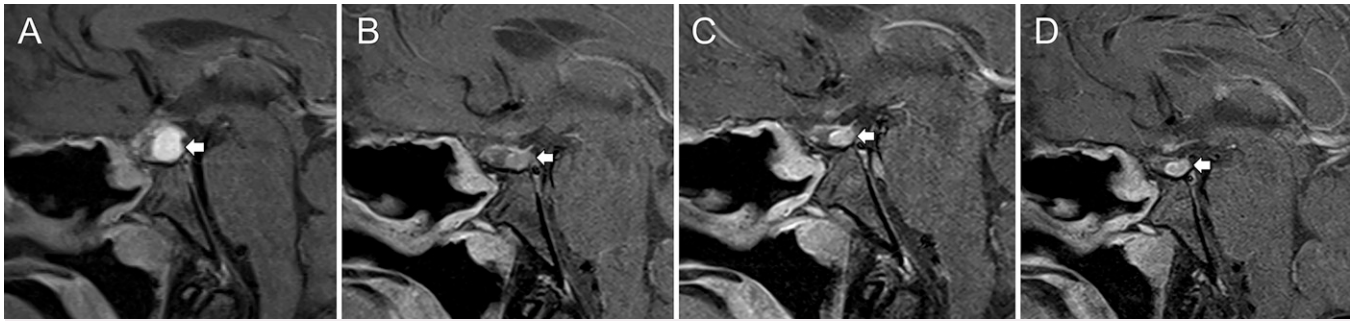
MRI at the second recurrence through treatment. A: Sagittal postcontrast T1-weighted MRI at the second recurrence showed a recurrent heterogeneous mass with hyperintense intrinsic T1 signal (*white arrow*) with heterogeneously enhancing tissue anteriorly and superiorly. No significant mass effect. B: Sagittal postcontrast T1-weighted MRI postdexamethasone shows decreased size of the sellar T1 hyperintense lesion (*white arrow*). C: Sagittal postcontrast T1-weighted MRI obtained after 4 months on celecoxib plus MMF, showing stable sellar T1 hyperintense lesion (*white arrow*). D: Sagittal postcontrast T1-weighted MRI obtained after 4 months off celecoxib but still on MMF, showing stable sellar T1 hyperintense lesion (*white arrow*).
